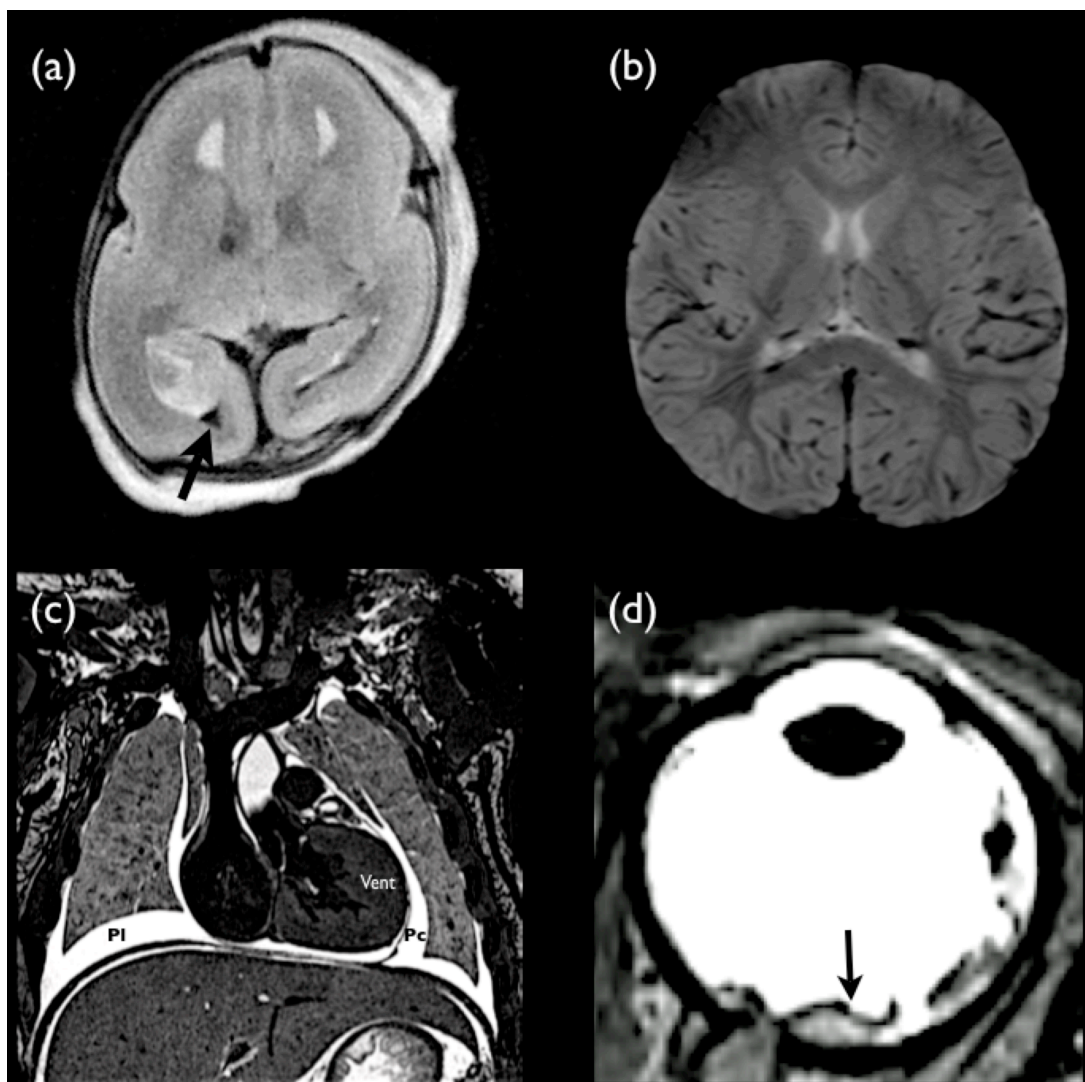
Other artefacts on post-mortem MR imaging
